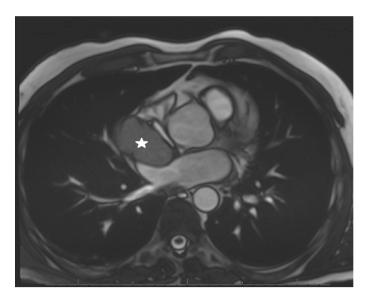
CMR T1-weighted images with heterogeneous, intermediate signal intensity mass (white star)
